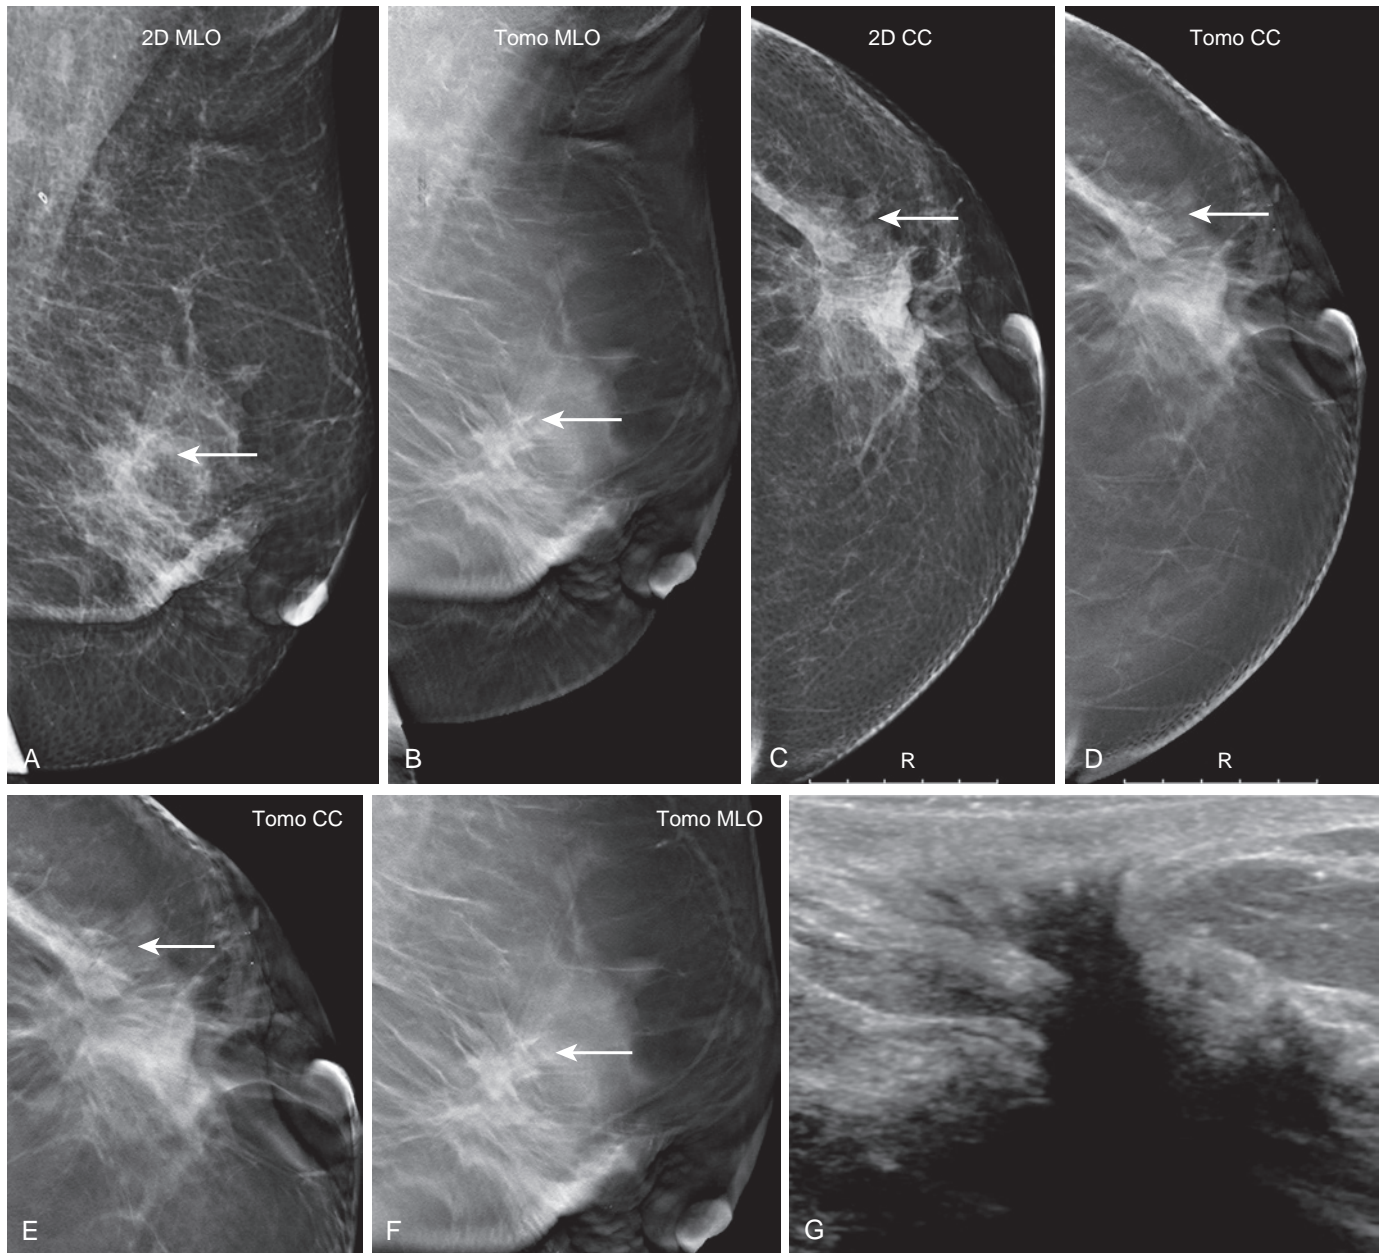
Tomosynthesis imaging in a woman with a personal history of breast cancer. A 54-year-old patient with personal history of mammographically occult left breast invasive lobular carcinoma presented for mammographic evaluation. (A-D) A new suspicious area in lateral aspect of the scar was identified on full-field digital mammography and tomosynthesis (*arrows*) imaging. (E and F) Close-up views of the area on tomosynthesis demonstrate improved visualization of a mass (*arrows*). (G) Ultrasound demonstrated an irregular mass corresponding to the mammographic finding, and ultrasound-guided core biopsy was performed resulting in diagnosis of recurrent invasive lobular carcinoma.
